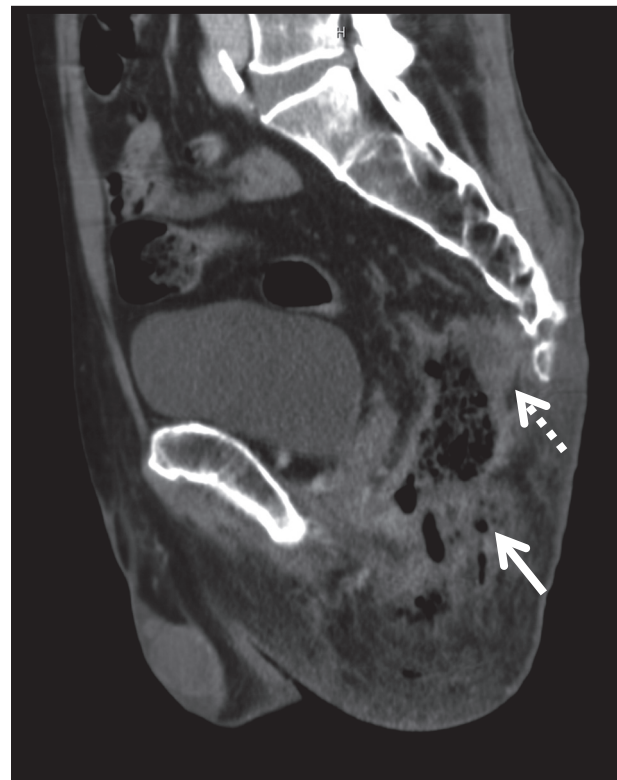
A contrast-enhanced computed tomography scan performed on admission detected partial defects in the rectal wall and a mixture of gas bubbles (white arrow) and liquid, which had spread from the tissue surrounding the rectum to the subcutaneous tissue, which were suggestive of necrotizing proctitis and the presence of a severe perirectal abscess (dotted white arrow).
